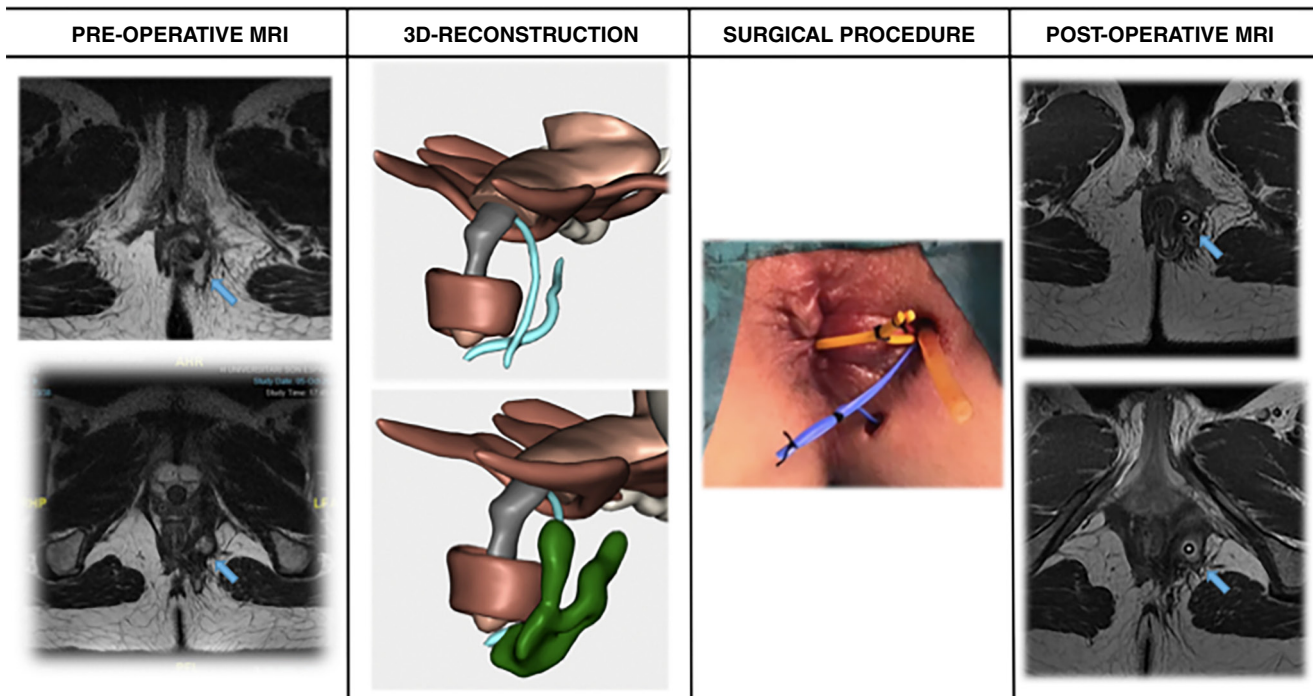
Summary of Case 2 (left to right): preoperative MRI, 3D-IPR, final view of surgical procedure, postoperative MRI. Arrows in preoperative MRI show abscess/fistula identification. Arrows in postoperative MRI show abscess resolution or drains in place.
